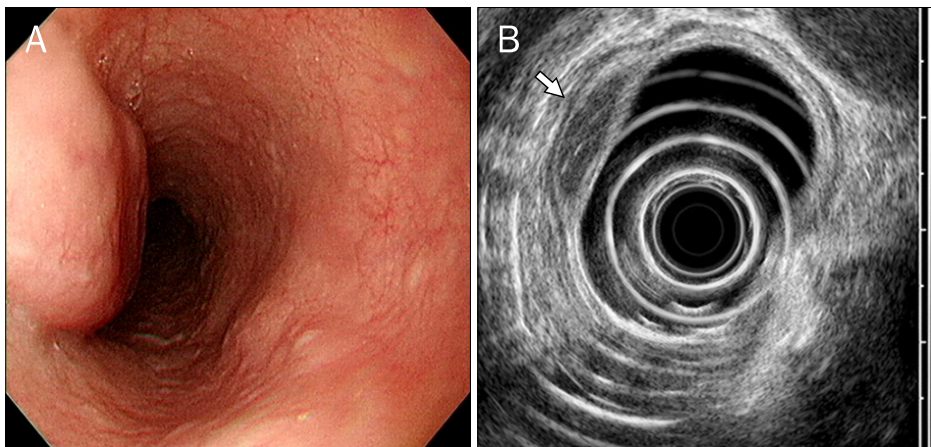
Endoscopic findings. (A) Endoscopic observation shows a cylindrically elongated submucosal mass in the mid esophagus (25-30 cm from the incisor teeth). (B) Endoscopic ultrasonography shows an ovoid homogenous hypoechoic mass (arrow) originating from the third hyperechoic layer (submucosa).
